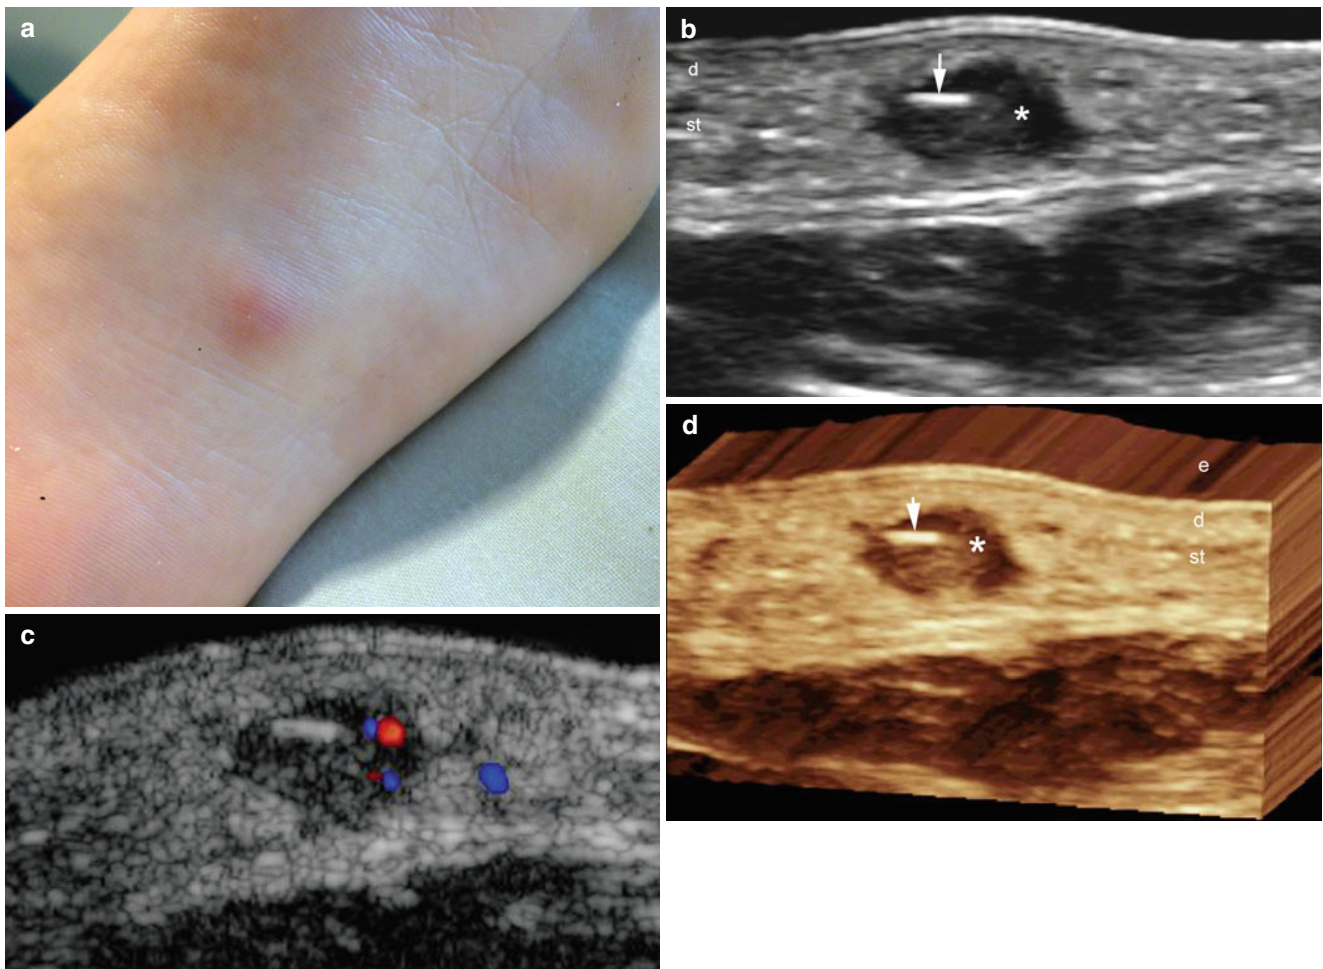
(a–d) Organic foreign body. (a) Clinical image shows erythematous swelling in the medial aspect of the sole of the left foot. (b) Gray scale ultrasound image (longitudinal view) demonstrates hyperechoic line (*arrow*) in the subcutaneous tissue that corresponds to a fragment of a splinter of wood. Hypoechoic granulomatous tissue (*)
